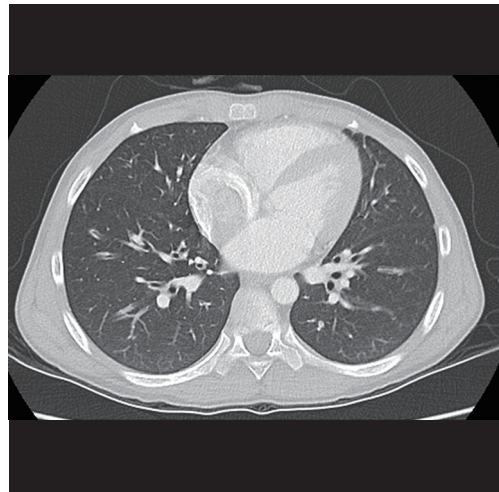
Chest computed tomography demonstrating diffuse, bilateral bronchial wall thickening, and tubular bronchiectasis.
